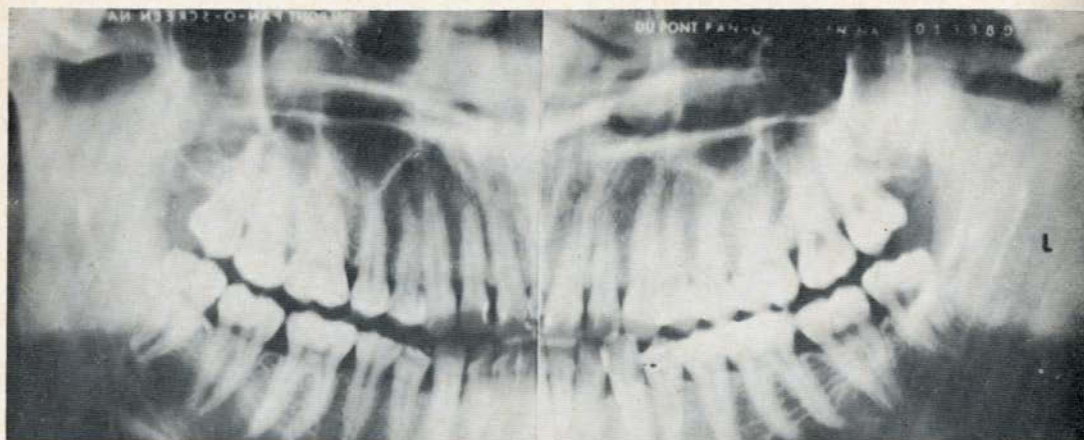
Panoramic radiograph showing abnormality of left Condyle.
